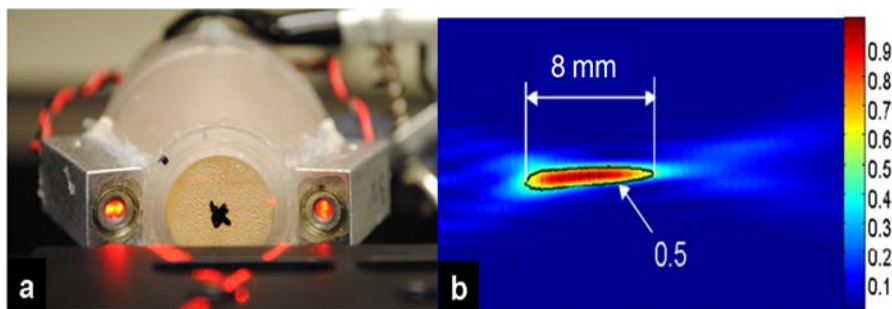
Non-magnetic focused ultrasound device. (a) The single spherically-focused ultrasound applicator with a laser localizer indicating the focus position, (b) the measured sound pressure squared (power).
